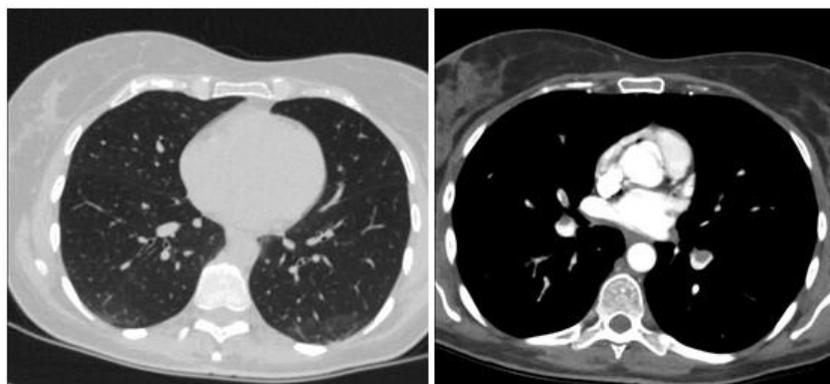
Contrast CT-scan
